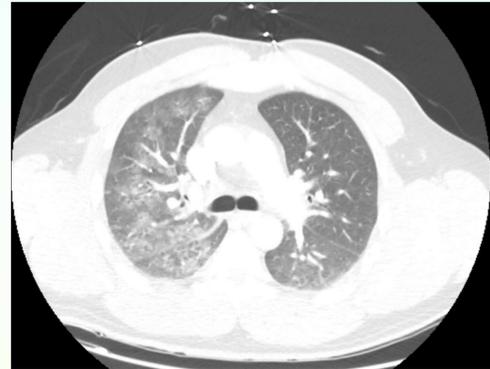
CT scan of the chest with intravenous contrast shows predominantly right sided ground glass opacities and interlobular septal thickening.
